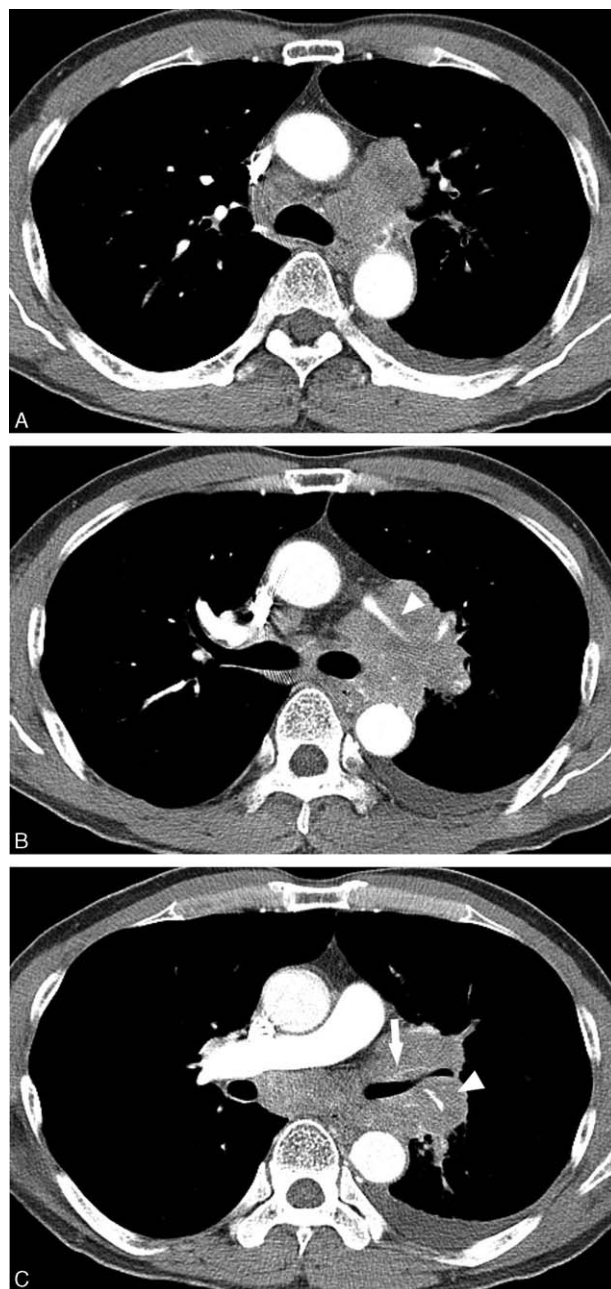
A 60-year-old male with SCLC (Type IIIb). (A, B, C) Axial CT mediastinal images show a left hilar mass with ipsilateral mediastinal conglomerate mass, encasing the left upper lobar bronchus (white arrow) and invading the left main and lobar pulmonary arteries (white arrowheads). Note the right lower paratracheal and subcarinal lymphadenopathies, and left pleural effusion. CT=computed tomography, SCLC=small cell lung carcinoma.
